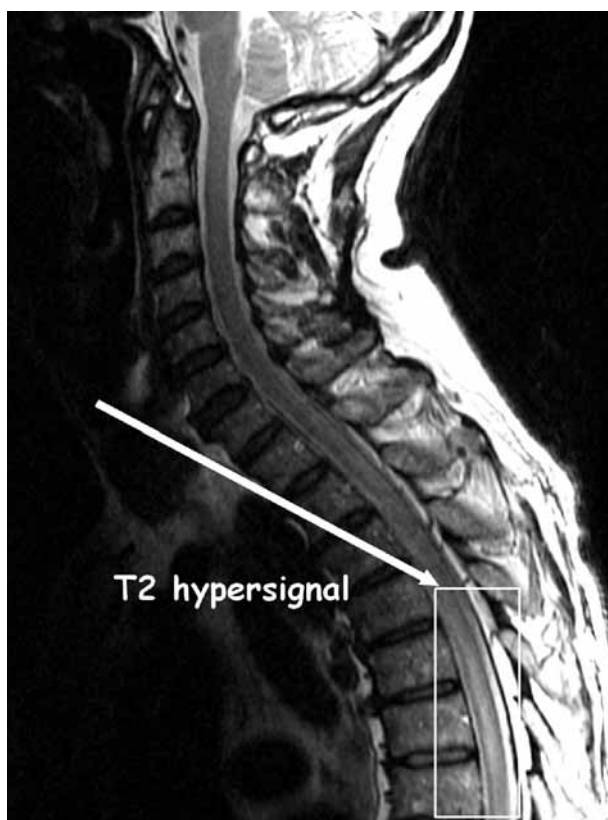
Magnetic resonance image (sagittal fast spin echo T2-weighted image) of the thoracic spine showing abnormal signal in the thoracic cord starting approximately at T2 extending to T10, consistent with cord infarct. There is no evidence of spinal/epidural haematoma.
